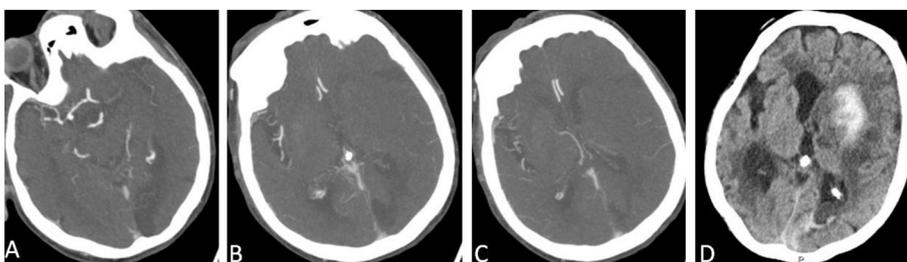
Exemplary representative axial CTA maximum MIPs demonstrate proximal occlusion of the left-sided M1 segment (A) with poor collaterals. Tan Score was 1 (< 50% of affected MCA territory opacified in comparison to non-affected MCA territory) (B + C). Infarction pattern with lesions of the entire basal ganglia, white matter, and associated cortex. Hyperattenuation due to parenchymal hematoma and contrast media extravasation within the infarct is shown (D).
